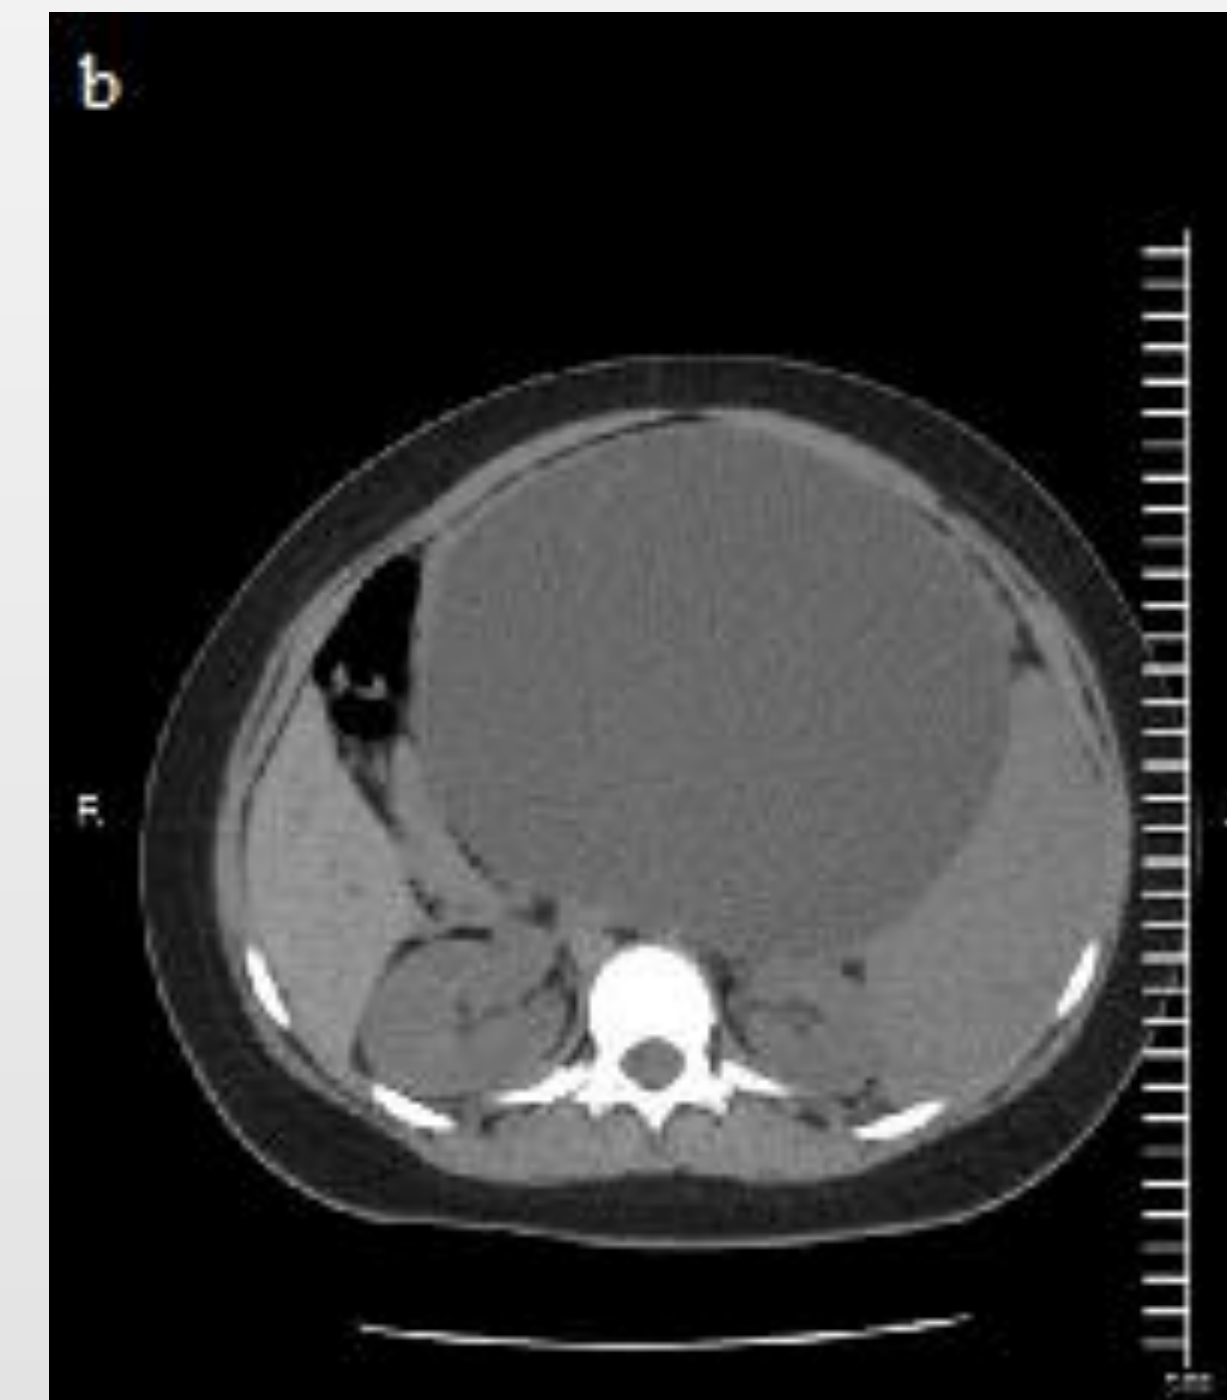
axial view on CT scan of the mass
